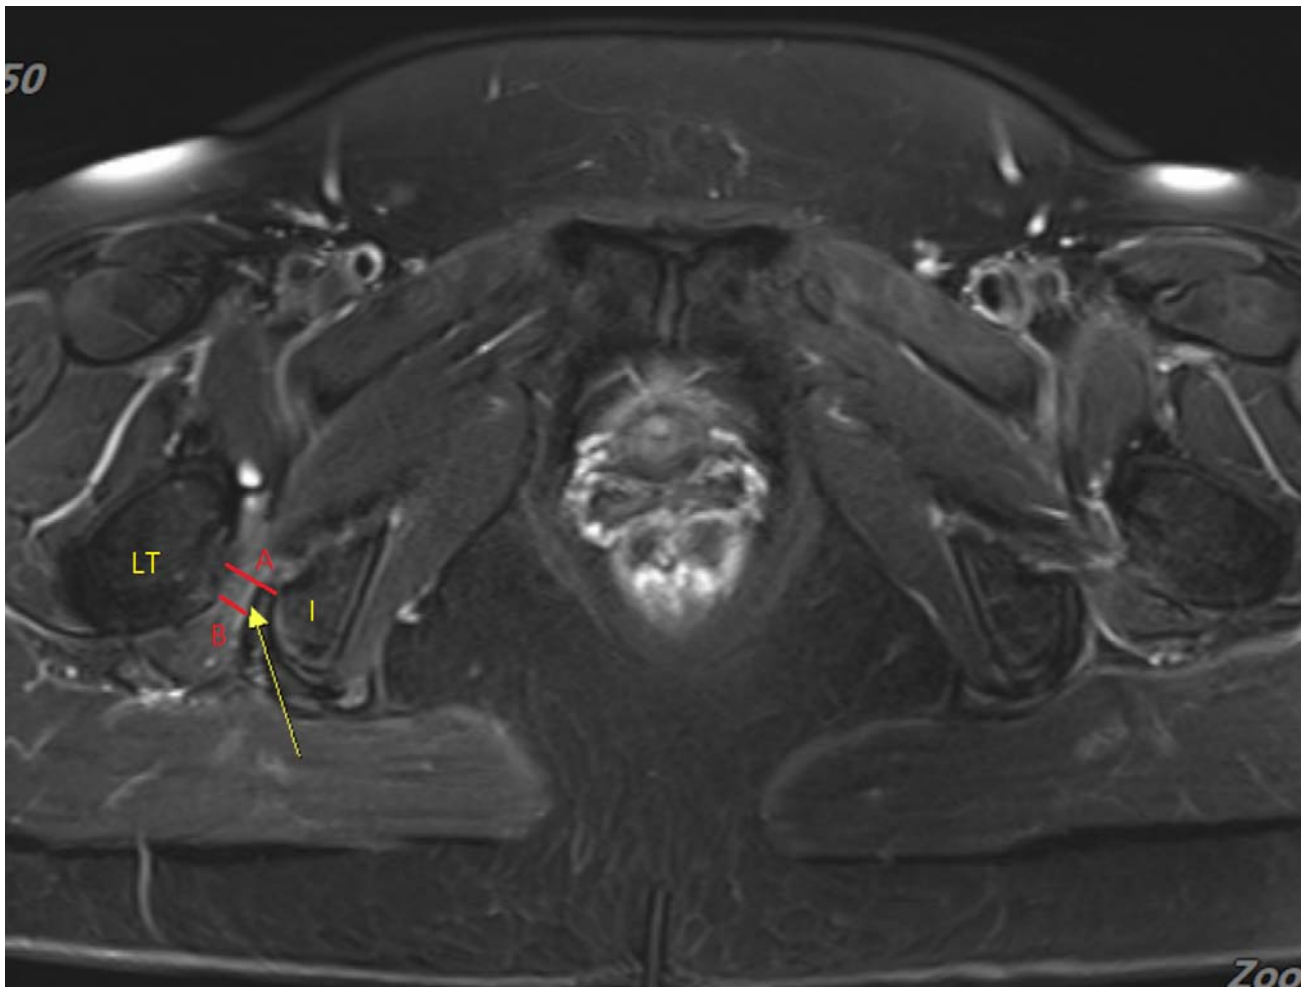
Pelvic MRI showed increased signal intensity over the right QFM (arrow) with a reduced IFS (distance between the ischial tuberosity and the lesser trochanter of the femur). LT=lesser trochanter, I=ischium, A line=IFS, B line=QFS.
